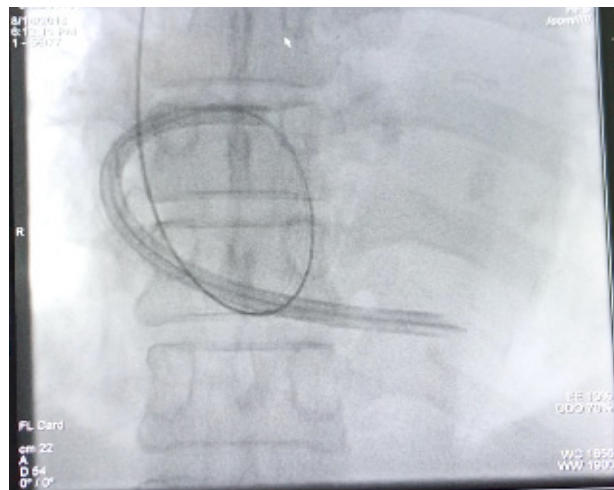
Fluoroscopy imaging showed fragmented TDC in heart chamber using the Mobile C-arm X-ray
